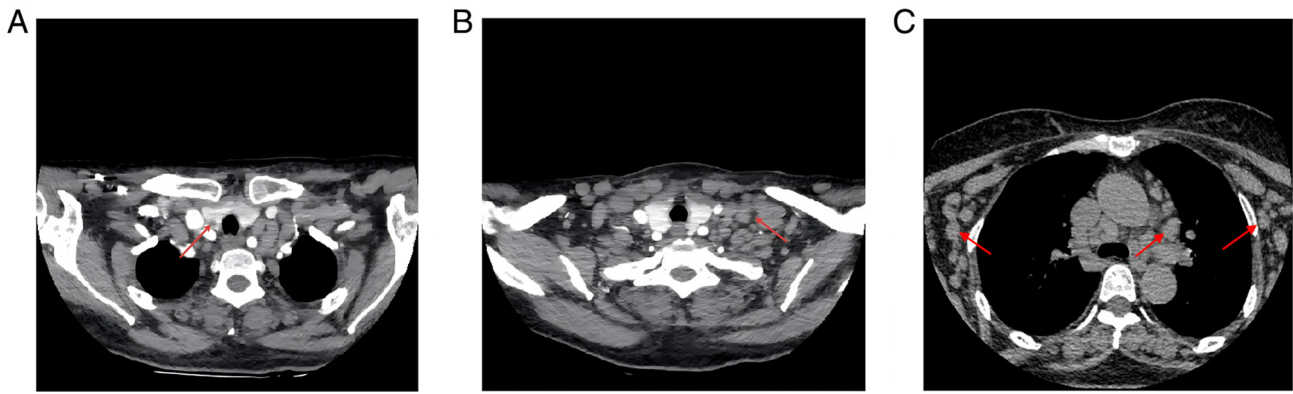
Baseline CT findings obtained during the initial diagnostic work-up at the index admission, showing multiple enlarged lymph nodes. (A) Contrast-enhanced neck CT scan at the level of the lung apices showing enlarged right cervical lymph nodes (red arrows), with the largest node measuring $\sim 2.0 \times 1.0$ cm. (B) Contrast-enhanced neck CT scan at the root of the neck showing enlarged left cervical lymph nodes (red arrows), with the largest node measuring $\sim 1.0 \times 1.0$ cm. (C) Chest CT scan showing multiple enlarged lymph nodes in the bilateral axillae and mediastinum (red arrows). CT, computed tomography.
